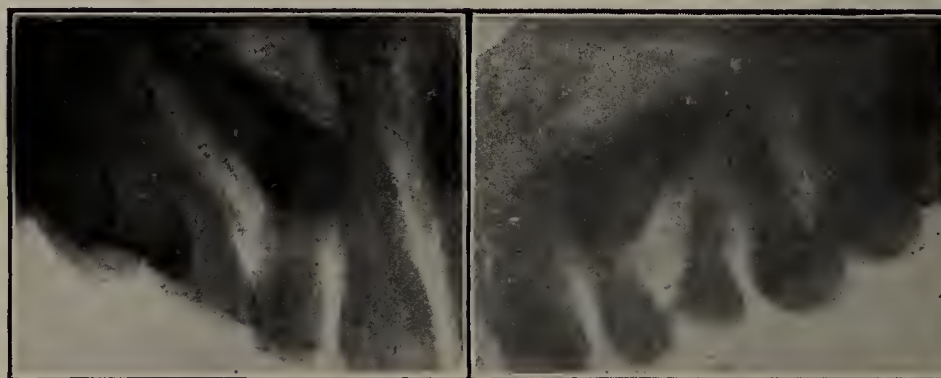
Patient of Dr. Price. Shows a case of delayed dentition. A girl at seventeen years of age still has her temporary cuspid, with no indication that the permanent has ever formed. The radiograph shows it to be imbedded against the central at an angle of about forty-five degrees. It is now being placed in its proper position. The gold of a crown is conspicuously shown on the next tooth.
